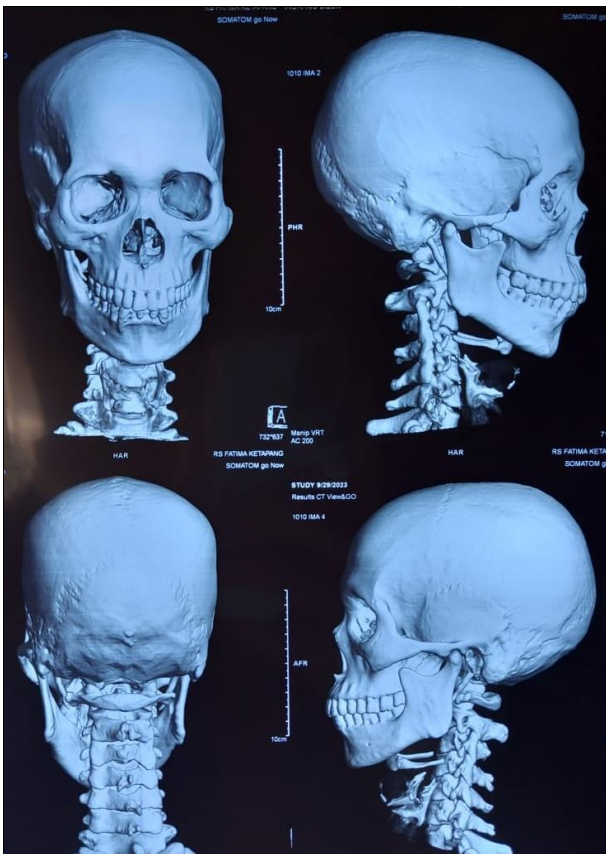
Three dimensional head CT scan after trauma
